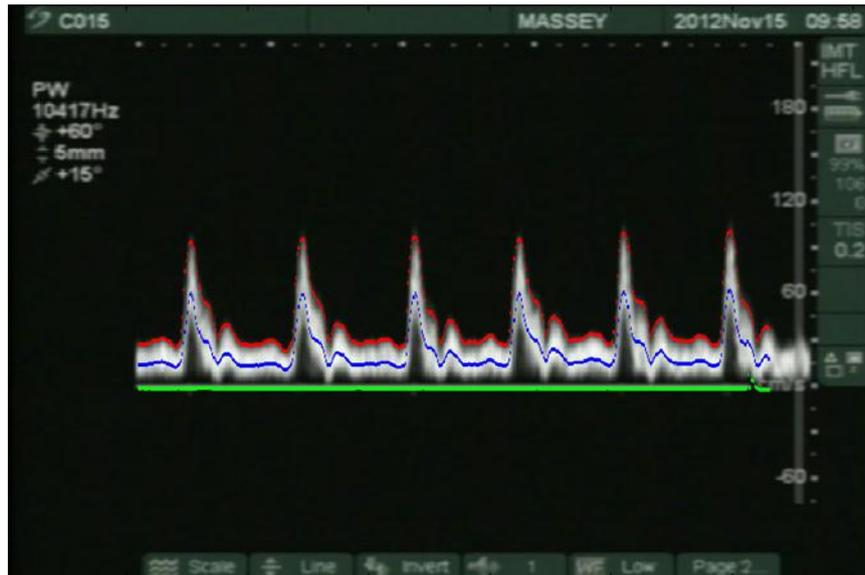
Analysis of the Doppler Spectral Trace. Representation of time average mean (blue line), maximum (red line) and minimum (green line) for each cardiac cycle over the 4.8 s period.
